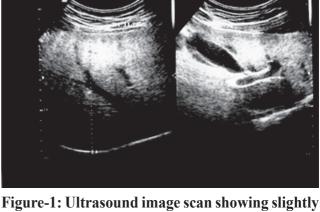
Ultrasound image scan showing slightly increased hepatic parenchymal echogenicity with well visualization of diaphragm and intrahepatic vessels borders (grade 1 fatty liver).
